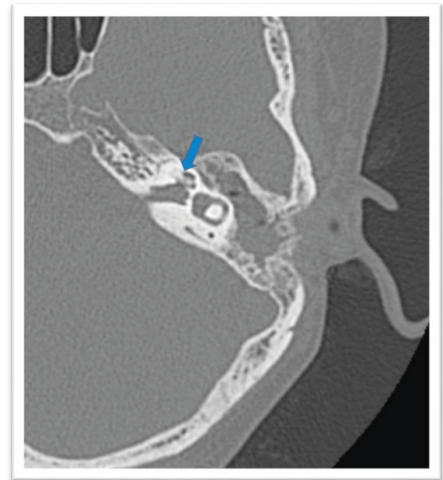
Computed tomography of the temporal bones, in axial section, without intravenous contrast, of a female patient, 52 years old, with a history of otitis media on the left, in the late postoperative period of radical mastoidectomy. Hyperdense material can be seen almost completely obliterating the basal and middle turns of the cochlea (blue arrow), compatible with labyrinthitis ossificans (LO), ipsilateral to the previous infection.
